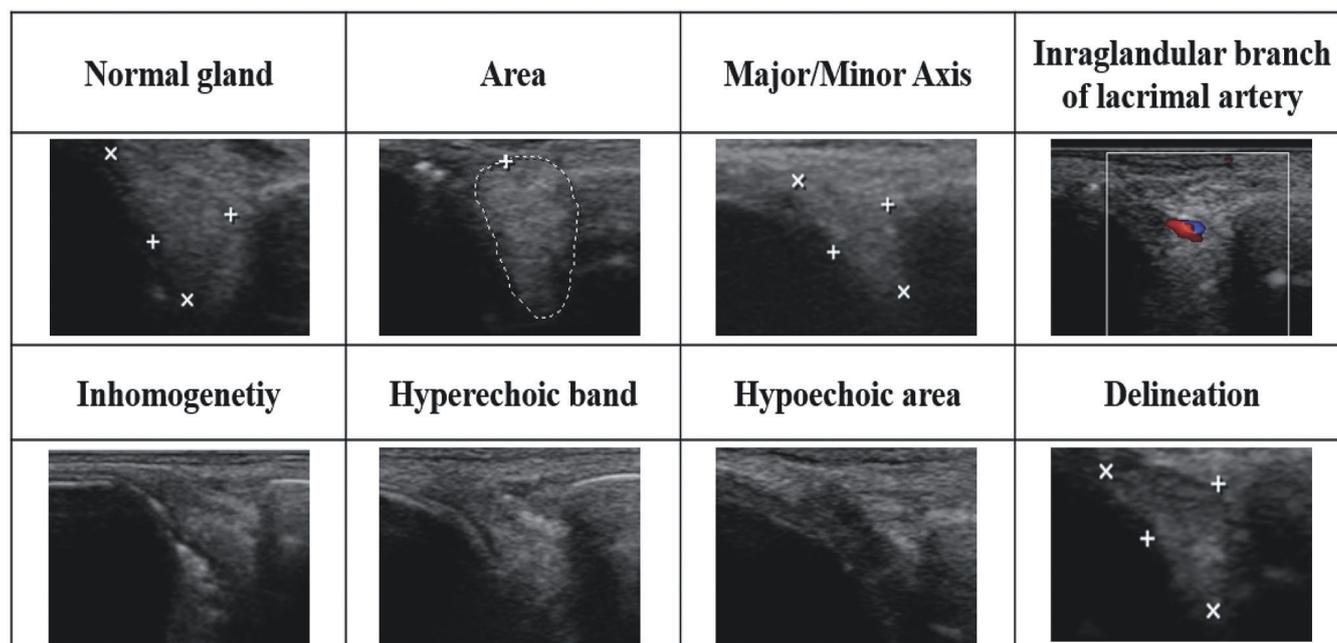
Examples of sonographic findings of lacrimal glands in study patients.
